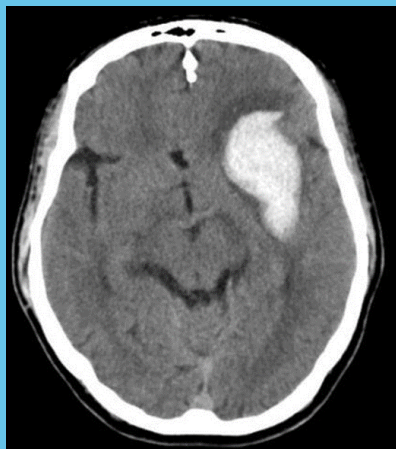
Non-contrast head CT shows a large left sided acute parenchymal hematoma which precludes treatment with IV tPA and additionally explains the patients symptoms. Additional forms such as subarachnoid or subdural hemorrhage if present would be a contraindication to IV tPA.
